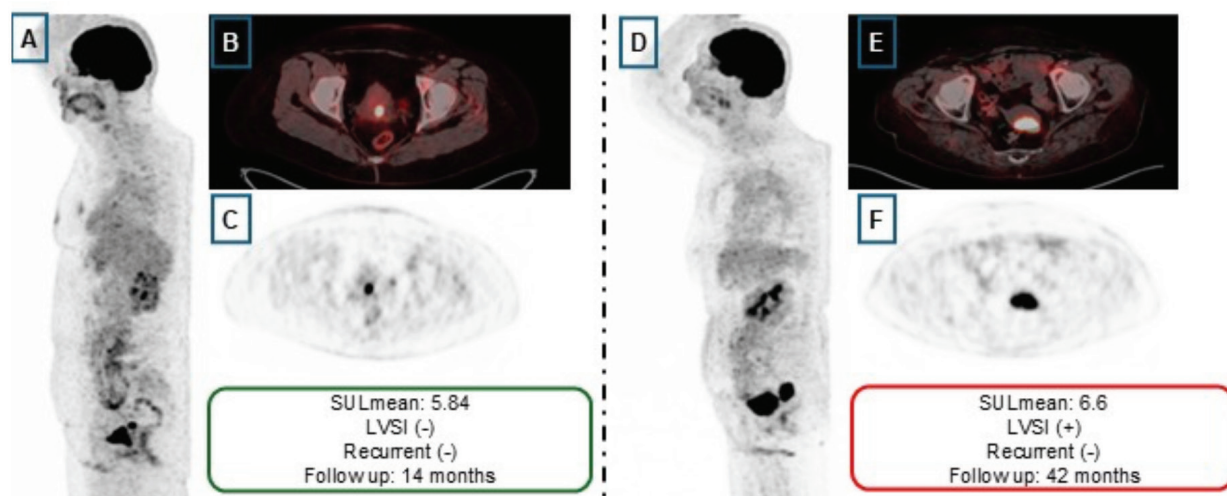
Representative ^{18}F -FDG PET/CT images of primary endometrial tumors according to LVSI status. (A-C) LVSI-negative case, (D-F) LVSI-positive case. (A, D) MIP images; (B, E) axial fused PET/CT; (C, F) axial PET images. Both patients were non-recurrent during follow-up
